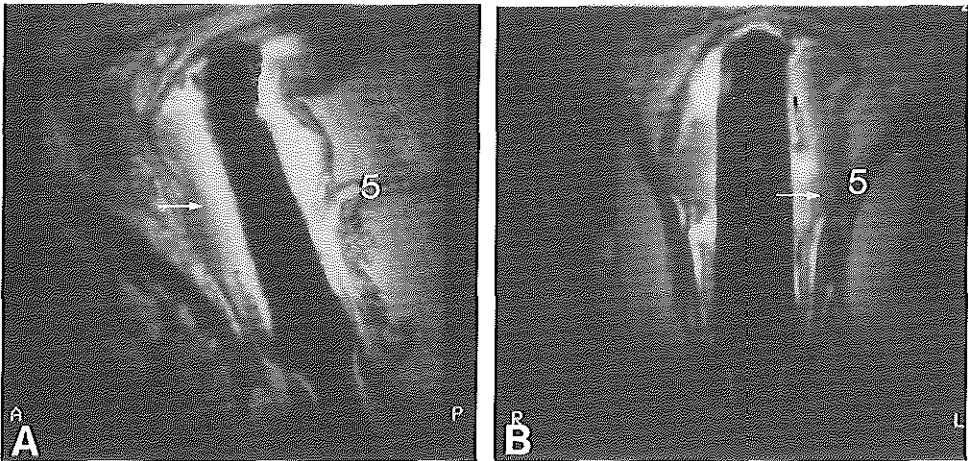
Sagittal (A) and coronal (B) endoanal MRI. Note the tumor (arrow) reaching below the level of the levator ani muscle (5).
